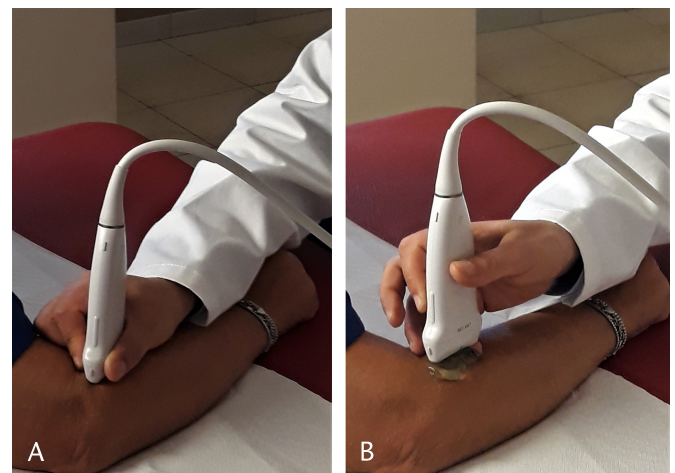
Appropriate use of the probe in dermatology ultrasound. A, The probe must be held firmly, with the operator hand over the patient body. B, A large amount of ultrasound gel must be placed between the probe footprint and patient skin (please note that the operator hand has been raised to allow recognizing the gel heap).
